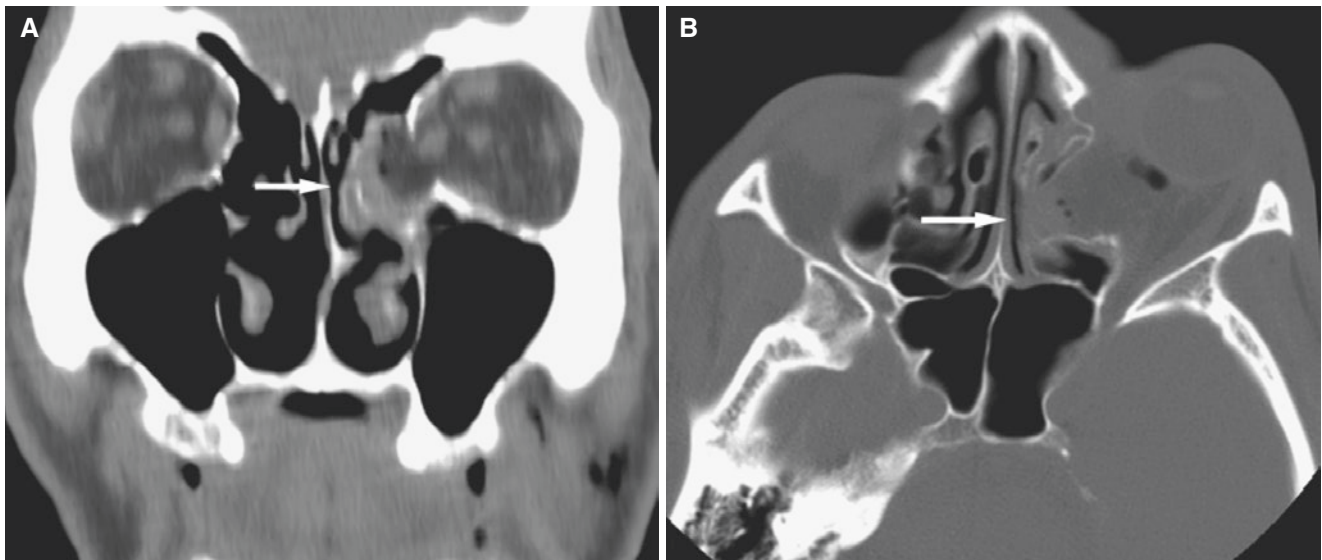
Blowout fracture, medial; 54-year-old male who was struck by a car from behind. (A) Coronal CT image shows fracture of the left medial orbital wall and soft tissue with periorbital fat in ethmoid cells
